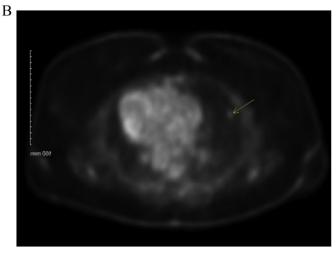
A: PET/CT scan showing mild FDG uptake in the Left Lower Lobe Nodule. B: PET/CT scan showing mild FDG uptake in the Right Middle Lobe Nodule.
